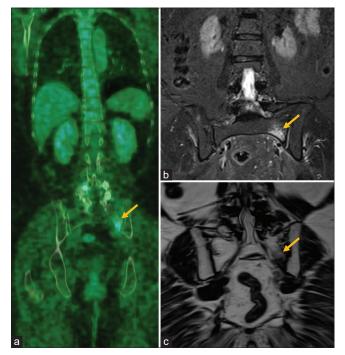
A 65-year-old female with carcinoma breast and bony metastasis in the left sacral ala. (a) Whole-body PET-CT image demonstrates focal uptake in the left sacral ala. (b) Coronal STIR image shows focal hyperintensity (arrow) without any hypointense fracture line. (c) Corresponding coronal T1-weighted image shows ill-defined hypointense signal without any definite fracture line.
